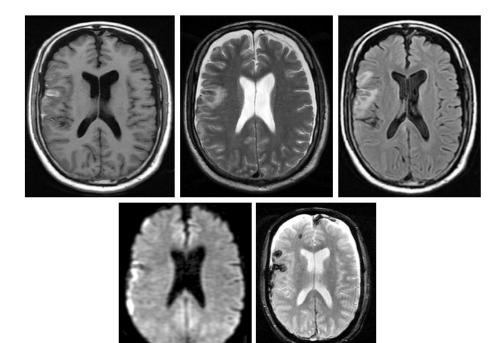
T1, T2 & FLAIR hyperintensities with DWI restriction and GRE blooming in right parietal sulcal spaces – s/o subarachnoid haemorrhage
